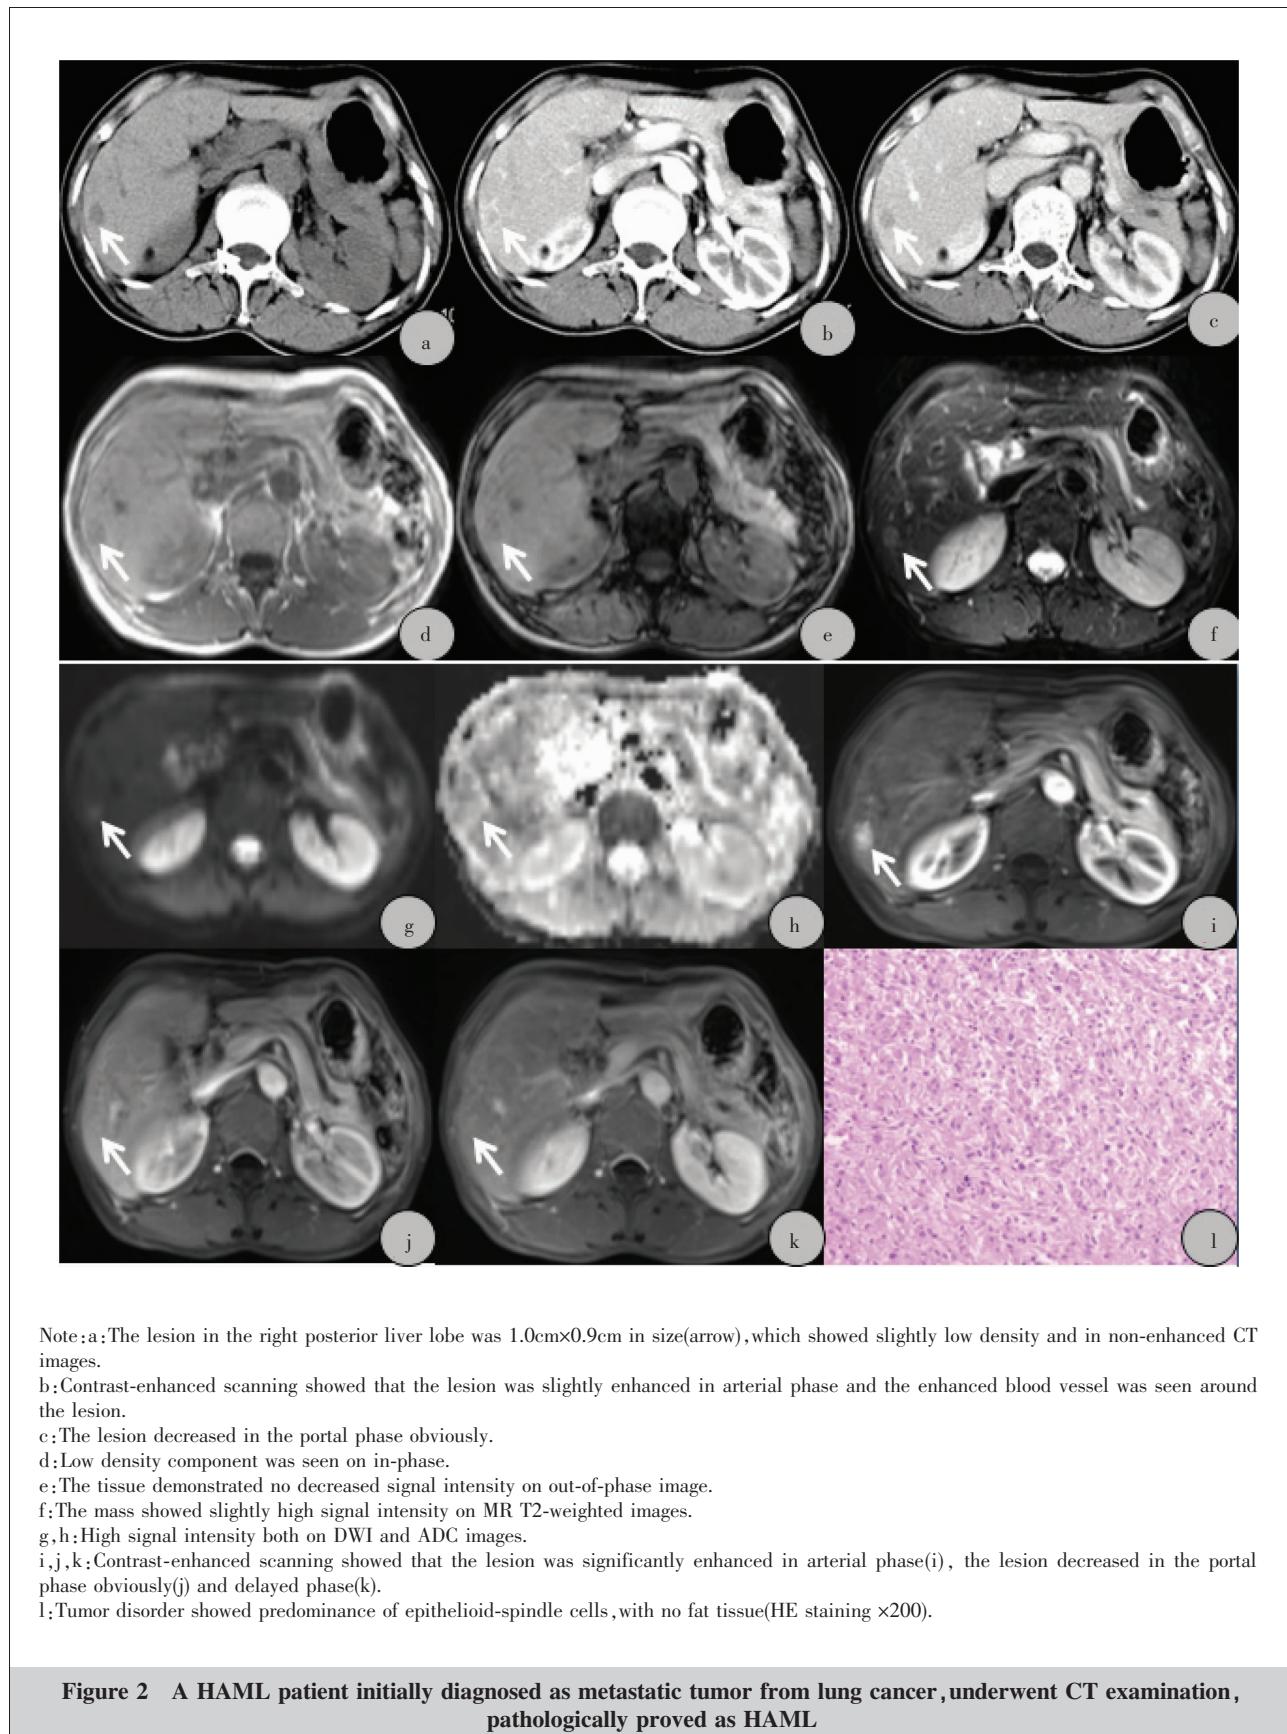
Pathological and CT features of a pathologically diagnosed HAML
